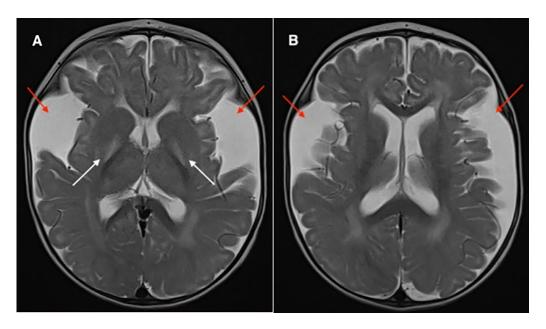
(A) Axial T2 MRI and (B) Axial FLAIR MRI shows a widening of the bilateral sylvian cisterns (red arrows) and T2 high signal intensity within the bilateral globus pallidus (white arrow in A) along with widening of the bilateral sylvian cisterns and subarachnoid spaces.
